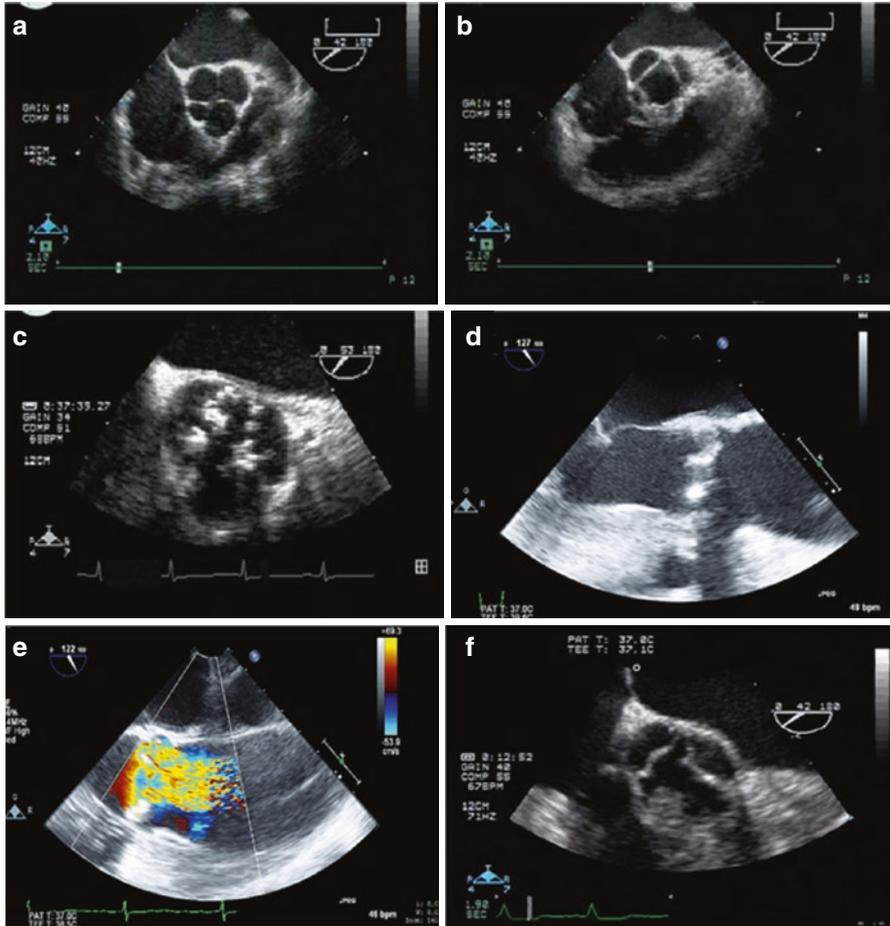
Normal AV in ME AV SAX view (a and b), severely stenotic AV in ME AV SAX (c) and ME AV LAX views (d), color Doppler (e) of severely stenotic AV showing turbulent flow at the aortic valve and root. Aortic sclerosis (f)
